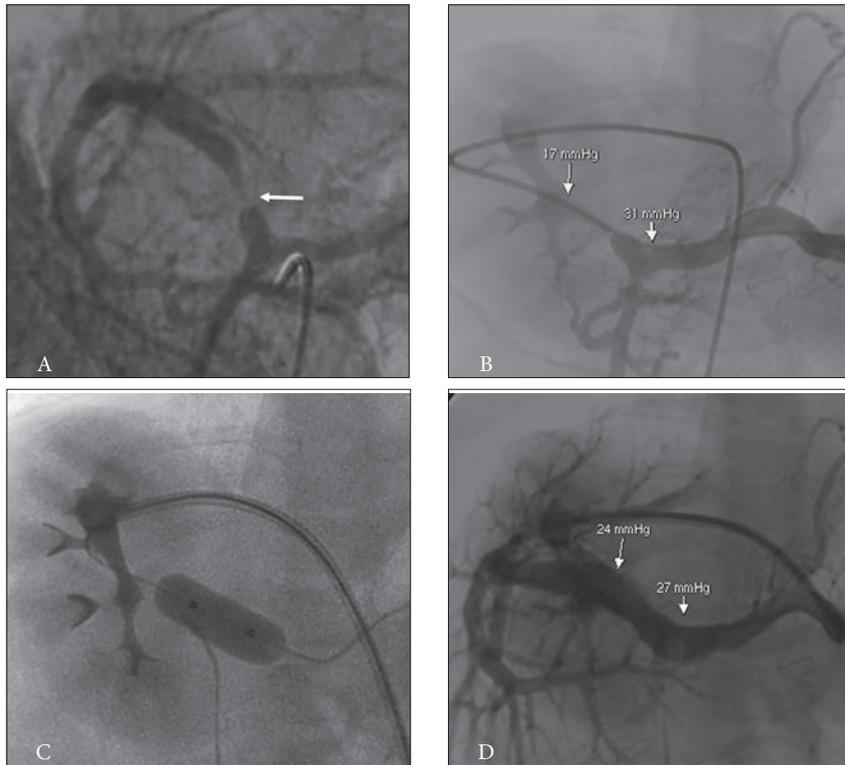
PVS in a 9-month-old with a split liver transplant for treatment of biliary atresia. Stenosis suspected on US. (A) Indirect portogram shows the stenosis at the portal vein anastomosis (arrow). (B) Direct transhepatic portogram shows the stenosis and filling of collateral veins, and allows measurement of the trans-stenotic pressure gradient of 14 mmHg. (C) Angioplasty with a 10 mm balloon catheter. (D) Post-angioplasty portogram shows resolution of the stenosis and a reduction in the pressure gradient to 3 mmHg. (PVS = portal vein stenosis; US = ultrasound.)
